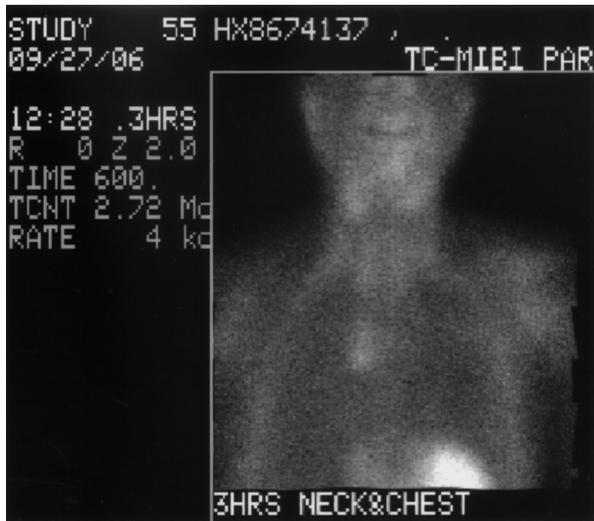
Tc99m-sestamibi parathyroid scintigraphy demonstrated a focal area of increased uptake involving the right side of the anterior mediastinum
